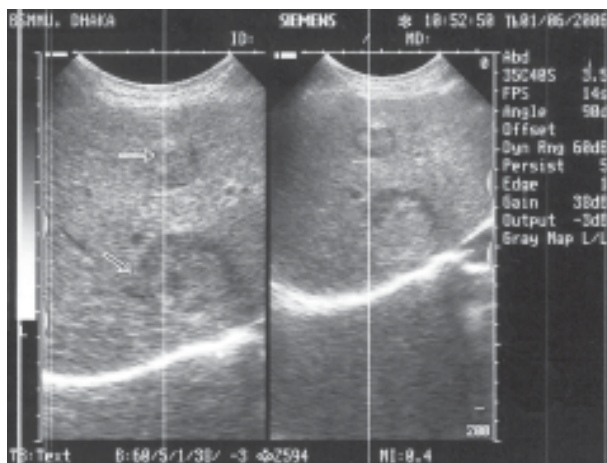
Sonographic image of multiple metastatic lesions of the liver (Bull's eye appearance) of a 58 years old female patient.
